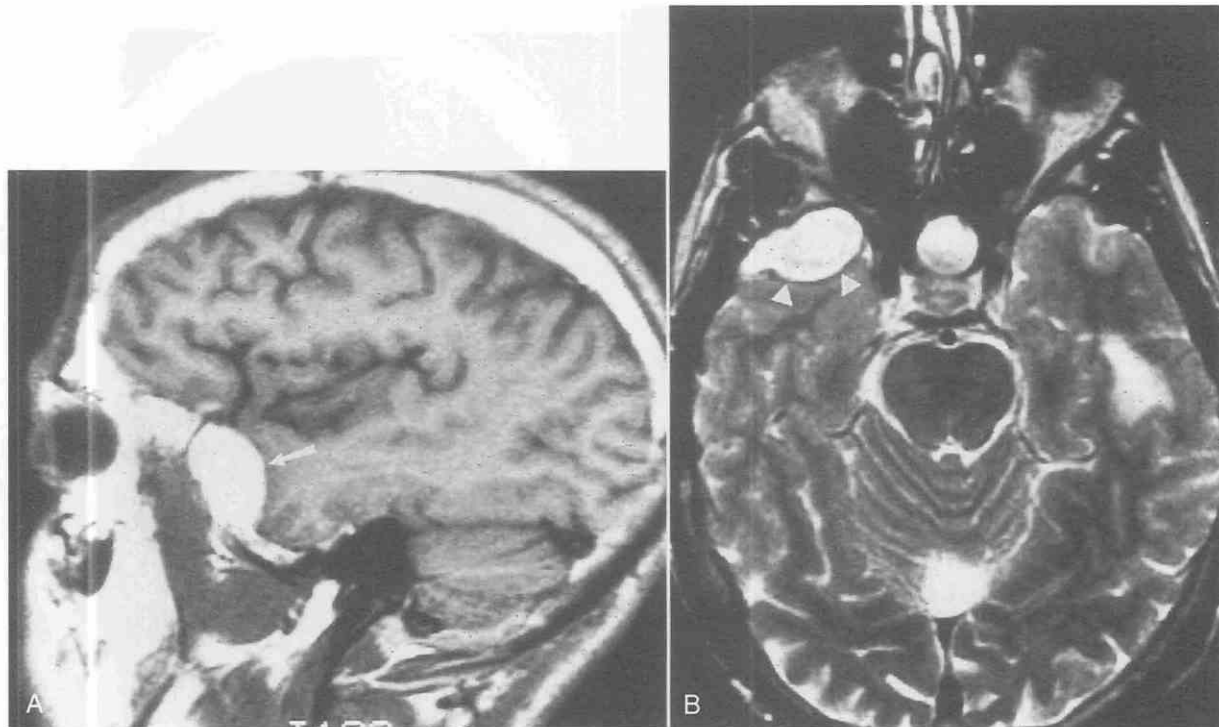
A and B, Subacute right temporal convexity epidural hematoma is hyperintense on both sagittal T1-weighted (500/15) (arrow) and axial fast spin-echo T2-weighted (4000/108) MR images (arrowheads). The band of hypointensity corresponds to the displaced dura (arrowheads). Retention cyst is present in the sphenoid sinus.
